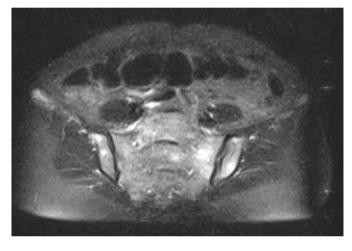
Sacroiliitis on T2 weighted magnetic resonance imaging of the sacroiliac joint.
